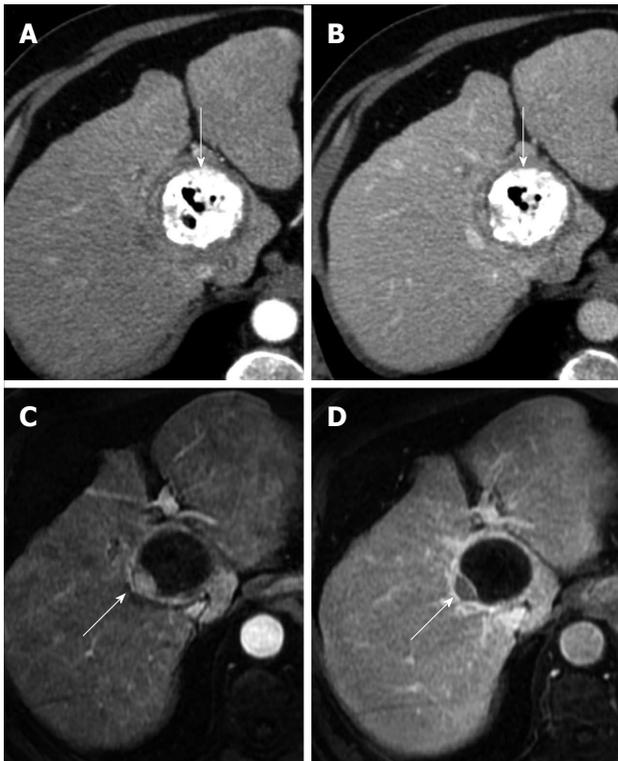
Incomplete hepatocellular carcinoma necrosis after transarterial chemoembolization. Arterial (A) and portal venous (B) phase computed tomography (CT) obtained 1 mo after transarterial chemoembolization (TACE) shows that hepatocellular carcinoma (HCC) is entirely replaced by Lipiodol accumulation (arrow). No evidence of residual tumor was found. Arterial (C) and portal venous (D) phase T1-weighted gradient-echo magnetic resonance (MR) obtained 1 wk after CT shows residual viable tumor (arrow) in the posterolateral portion of the tumor. This case shows higher accuracy of MR in comparison to CT in assessing HCC response after TACE.
